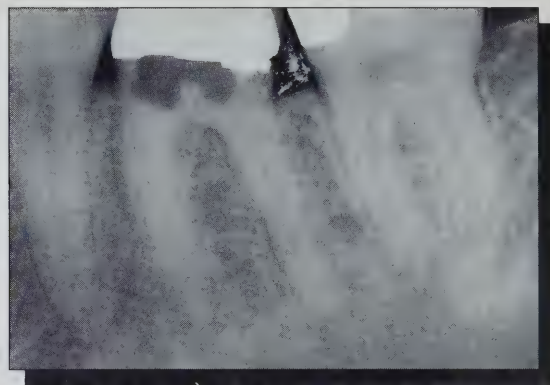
This radiograph shows the effects of gouging during an attempted access opening of an excessively calcified chamber. A crown was placed a short time previously, and the pulp became symptomatic. Fortunately, there was no sign of perforation and all three canals could be located with the help of fibre-optic illumination.
